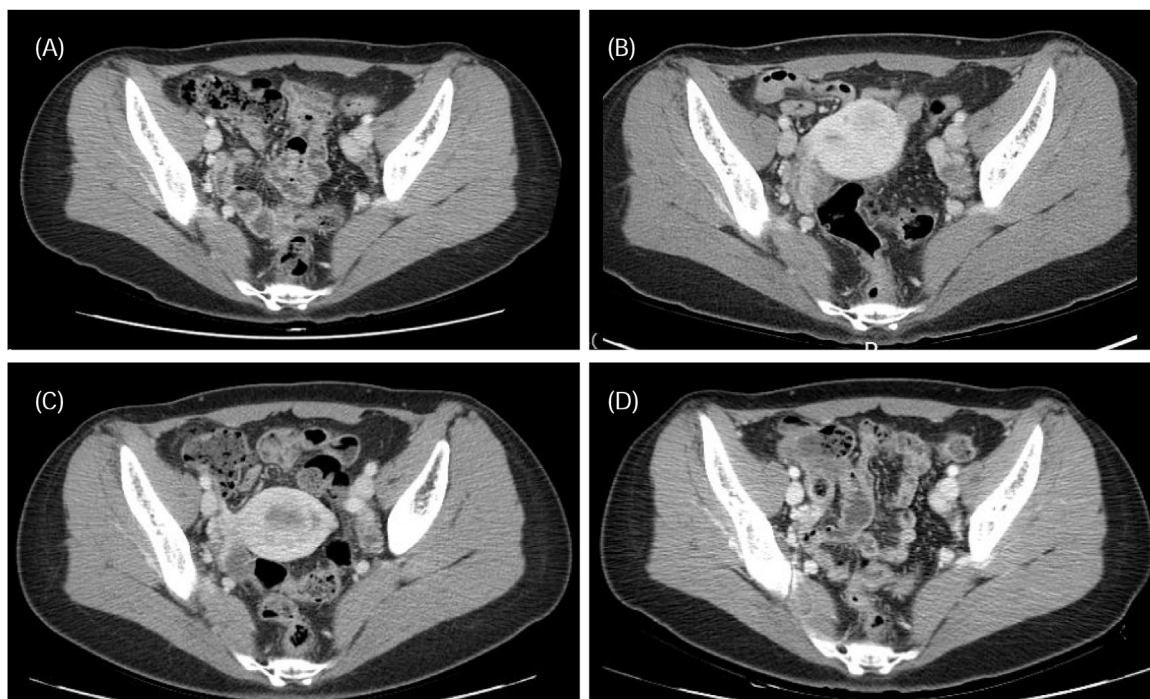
CT scan of pelvic area presenting no recurrence of endometriosis. (A) Ten months after starting TKM treatment. (B) Twelve months after starting TKM treatment. (C) Eighteen months after starting TKM treatment. (D) Twenty-nine months after starting TKM treatment.
